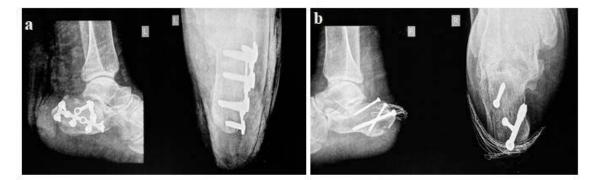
Post operation view; (a): Post op day 11 x-ray for plating of left calcaneum in lateral and axial views; (b): Post op day 11 x-ray for screw fixation of right calcaneum in lateral and axial views
